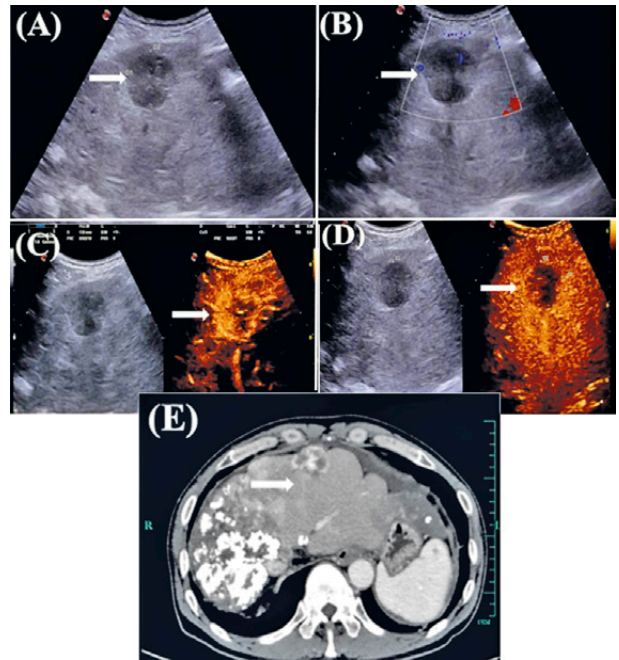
HEHE in a 66-year-old male patient with positive hepatitis B core antibody and negative AFP, CA125: 73.3 ng ml⁻¹, CEA: 5.2 ng ml⁻¹: (A) A hypoechoic lesion with clear boundaries and a size of 3.5 × 3.2 cm was observed under the right liver capsule; (B) Color Doppler flow imaging reveals short strip blood flow signals within the lesion; (C) The lesion displays mild to moderate uneven high enhancement during the arterial phase, observed within 30 s; (D) At 92 s, the lesion shows low enhancement; (E) Multiple lesions and calcifications are detected in the right liver during the arterial phase of CT scanning.
